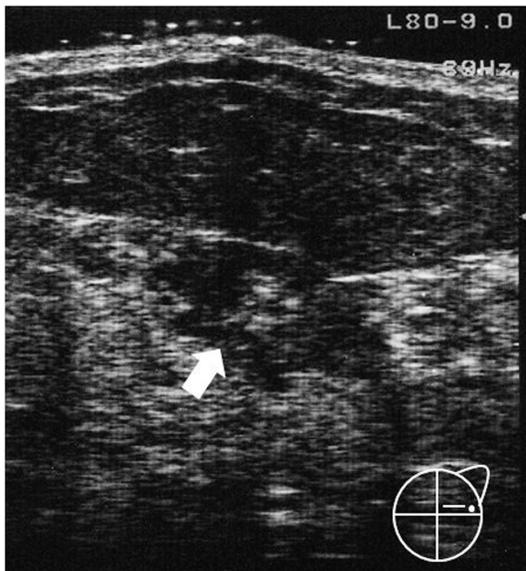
Ultrasound findings in the primary lesion.
